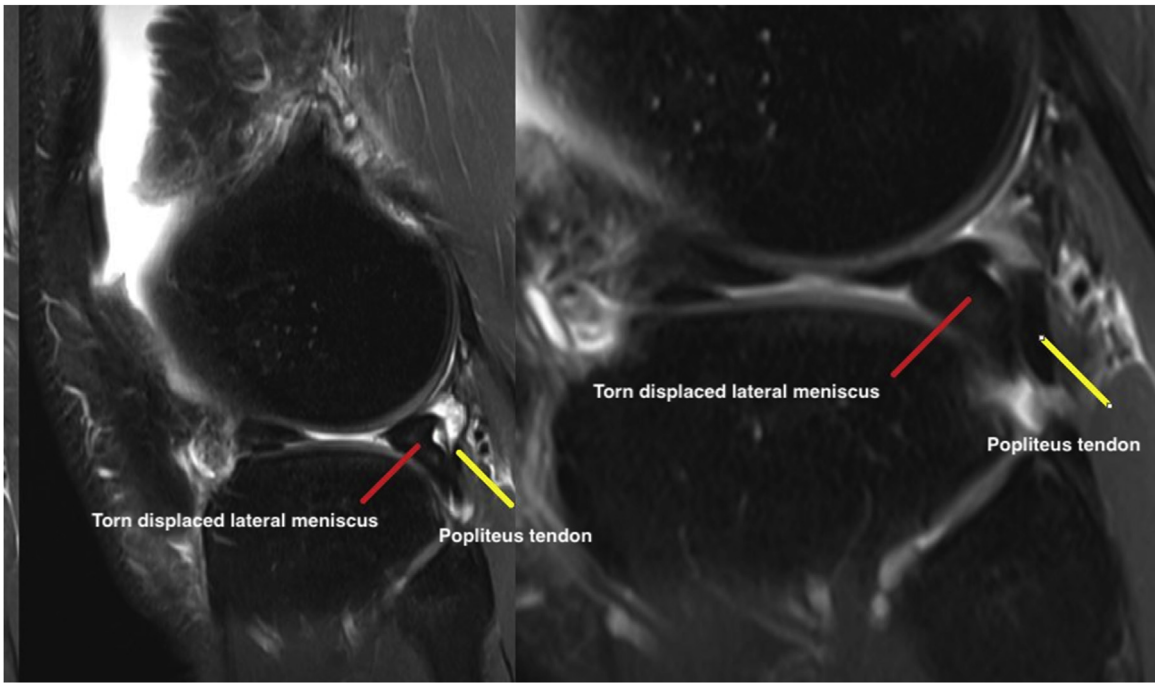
Sagittal T2 MRI cuts showing Double popliteus sign.
